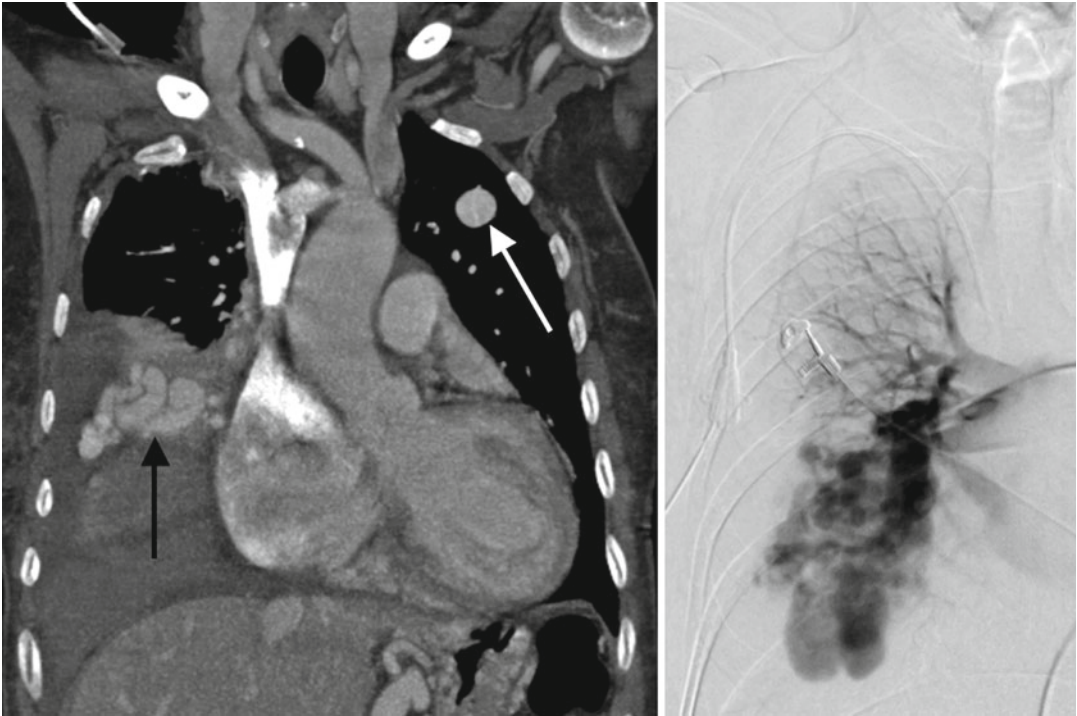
Coronal reconstruction of an i.v. contrast-enhanced spiral-CT data set demonstrating multiple pulmonary AV-malformations (*arrows*) in a 75-year-old female patient (*left image*). Prior to this control CT, patient underwent CT-guided biopsy (without contrast
